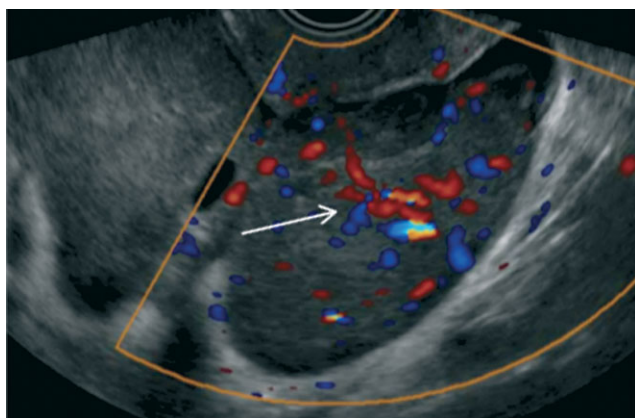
Color Doppler examination of ovarian mass showing rich vascularization and in particular a main tree-shaped vessel, corresponding to the so-called 'lead vessel' (arrow).
